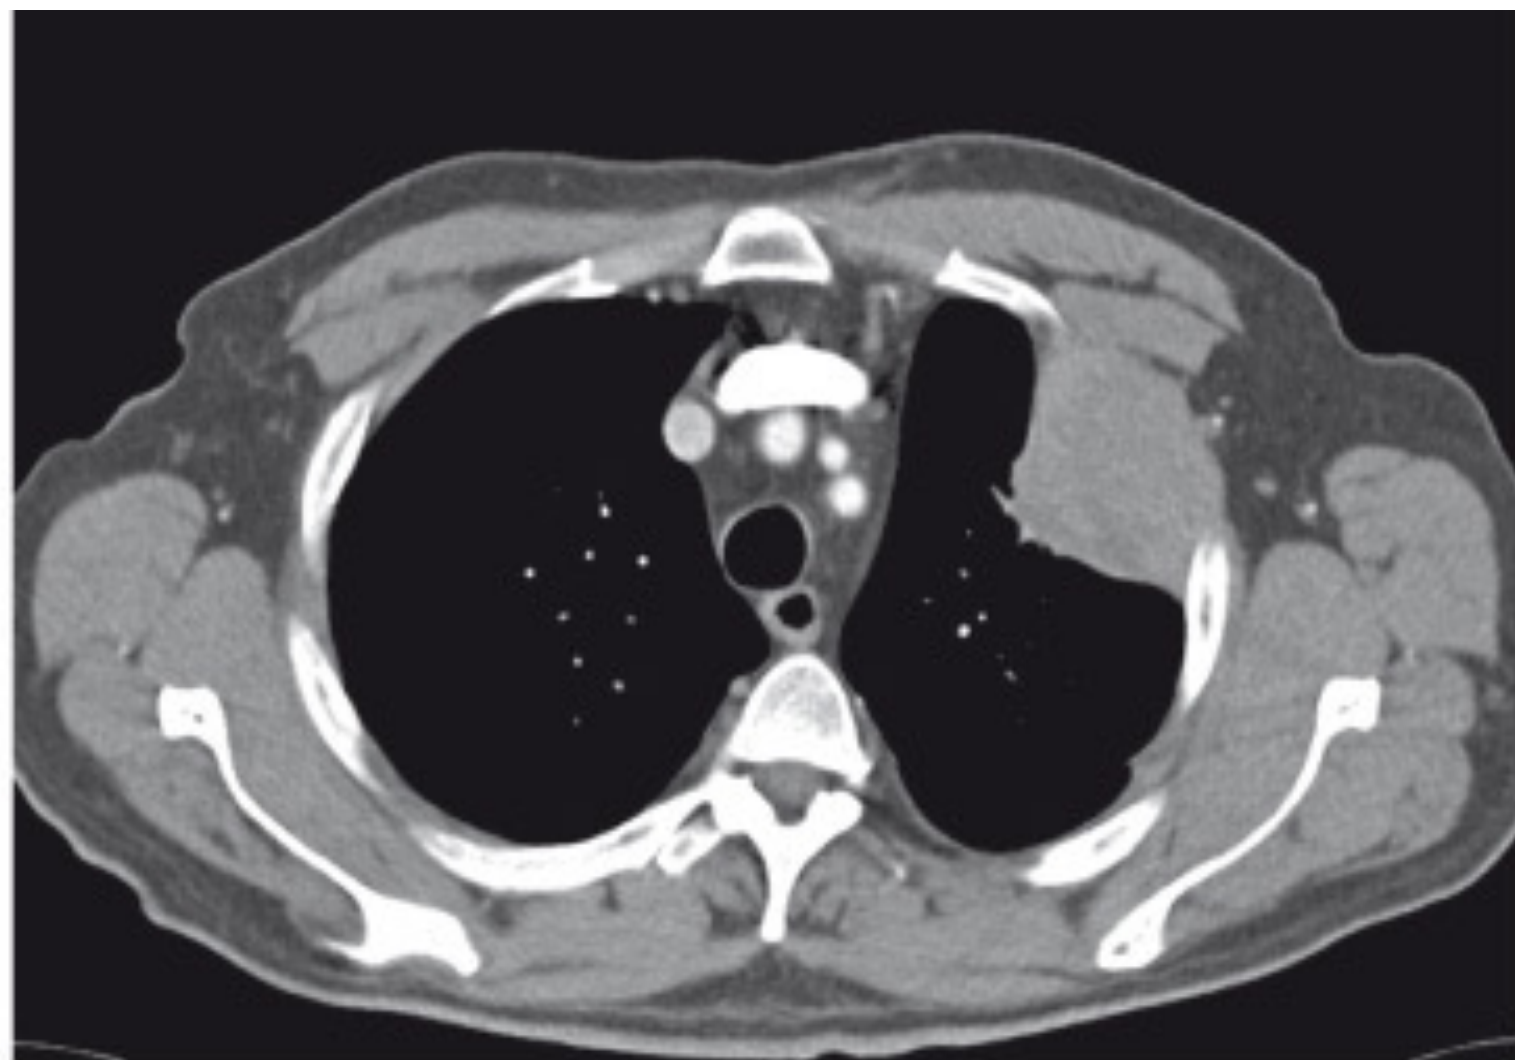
Chest computed tomographic scan of a T3 N0 left upper lobe non-small cell lung cancer with chest wall invasion.
